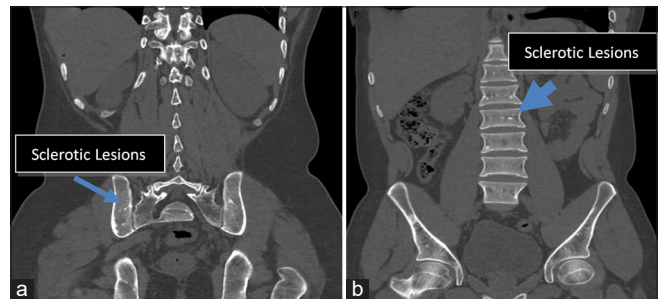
Coronal bone window computed tomography image of the abdomen shows few small sclerotic lesions in bilateral ilium (blue thin arrow) (a) and vertebral bodies (blue thick arrow) (b).
